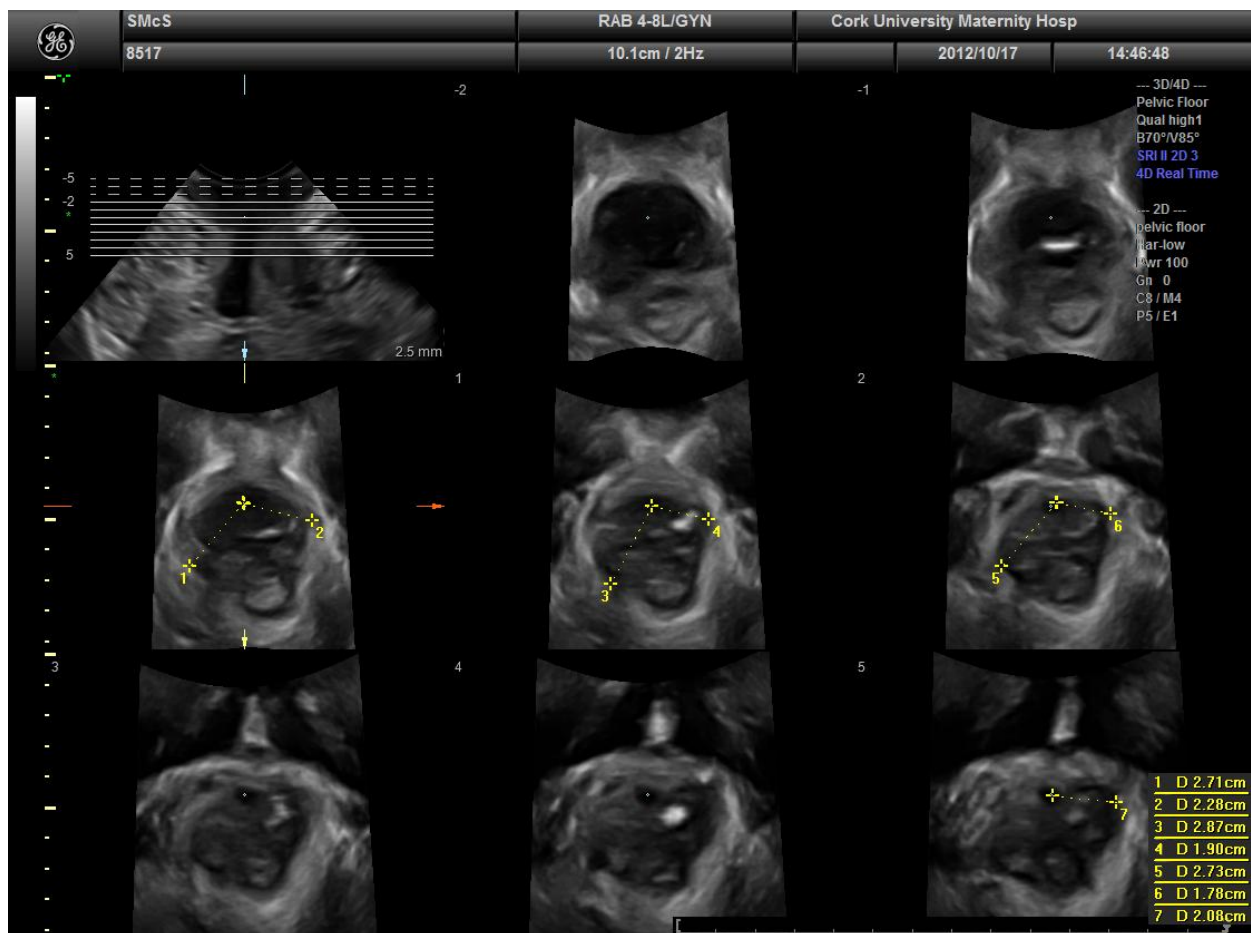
Tomographic Ultrasound Investigation mode
